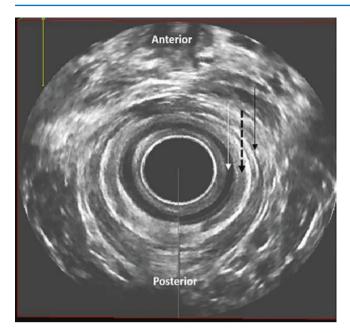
Endoanal ultrasound. A sagittal view of the anal sphincter complex. The white arrow shows the internal anal sphincter, the dashed arrow shows the longitudinal muscle and the black arrow the external sphincter
